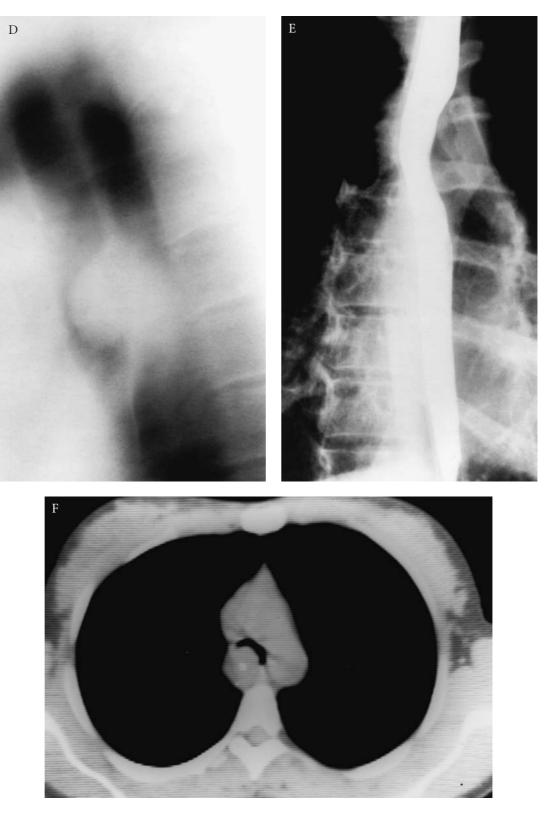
(CONTINUED) D, Lateral tomogram demonstrates the posterior location of the base of tumor. E, Barium esophagogram shows smooth indentation of the esophagus by the mass. F, Computed tomography scan clarifies the component of tumor extending beyond the tracheal lumen. Carinal resection was required for an adequate margin, and was followed by radiotherapy. She remained well and without recurrence 19 years later.
